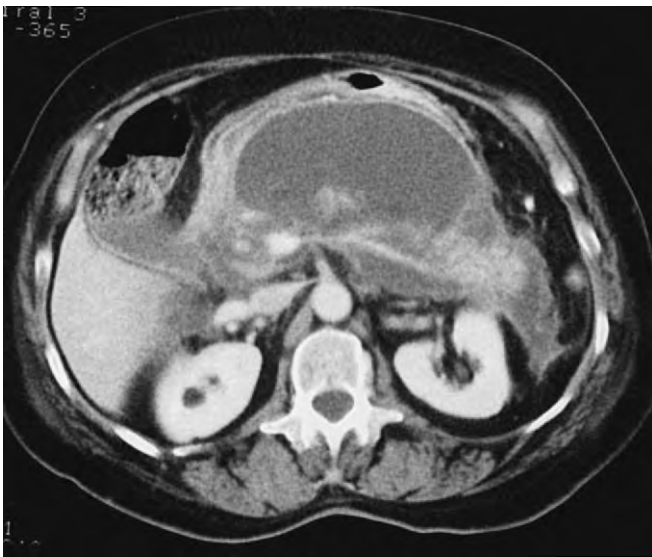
Computed tomography scan of a patient with a large retrogastric pancreatic pseudocyst. The patient had symptoms of abdominal pain, back pain, nausea, and early satiety.
